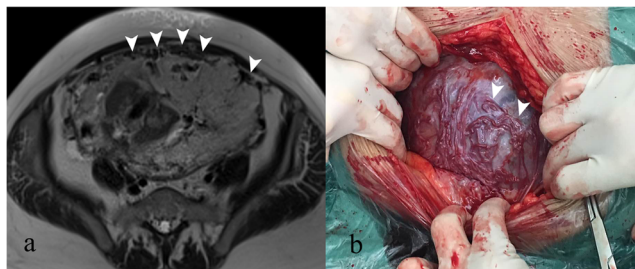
Placenta percreta (PP) in a 35-year-old woman at 29 weeks' gestation. (a) Axial T2-HASTE image demonstrates uterine serosal hypervascularity (arrowheads, tortuous and closely packed vessels along the uterine serosa) in the lower uterine segment. (b) Photograph taken during caesarean delivery shows these tortuous abnormal vessels in the uterine serosa (arrowheads), consistent with the appearance on MRI images
